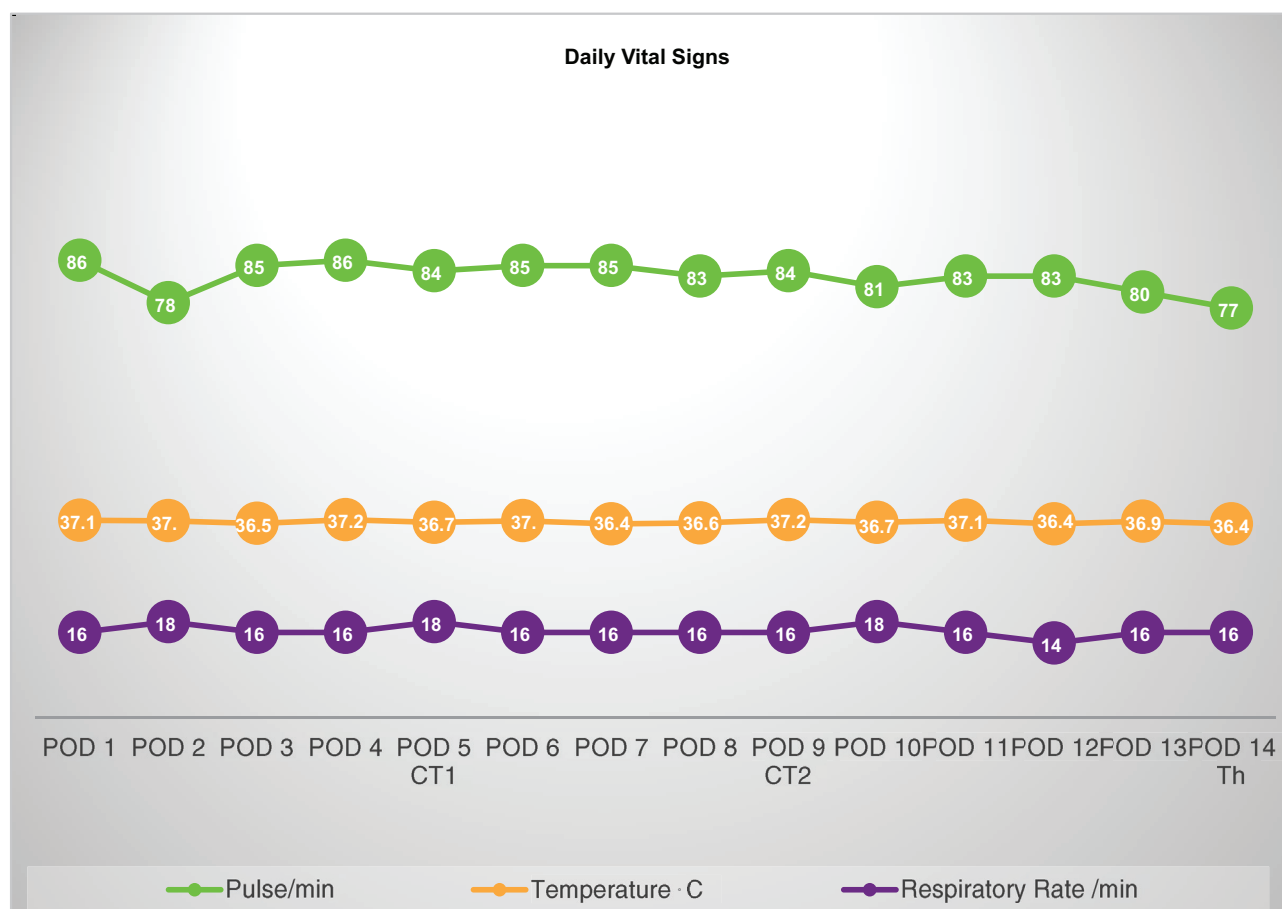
Median daily vital signs criteria for Systemic Inflammatory Response Syndrome (SIRS). POD – post-operative day, CT1 – the first CT scan performed on the fifth POD, CT2 – the second CT scan on the ninth post-operative day, TH – return to theatre on POD 14 and Min – minutes.
